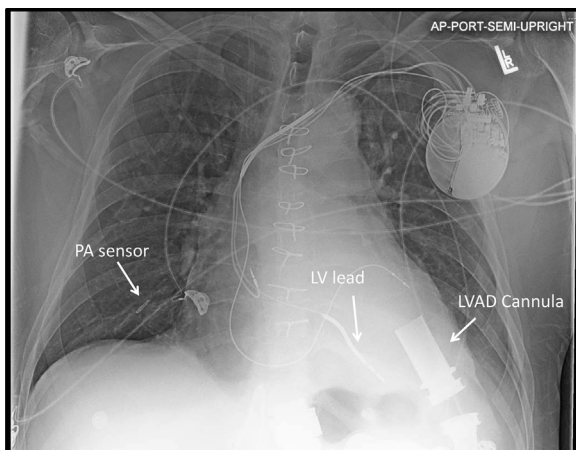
Chest radiograph revealing implanted devices, including pulmonary artery (PA) pressure sensor and chronic high-voltage lead. LV = left ventricle; LVAD = left ventricular assist device.
